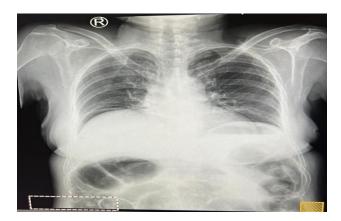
X-ray chest of the patient showing air under right dome of diaphragm.
